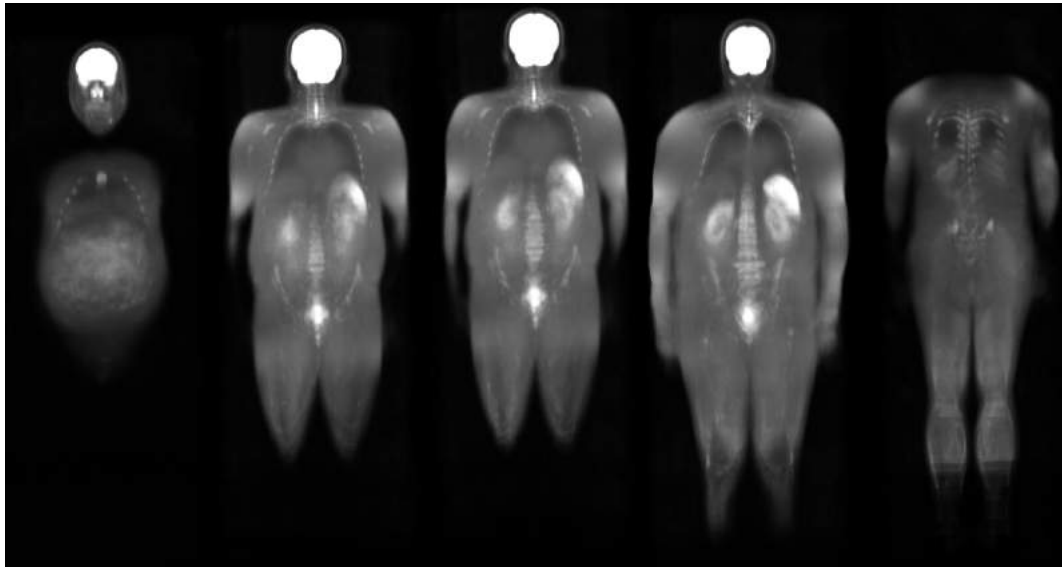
Male template image, built with 18 DWI images and using the first template image built with 18 images as the fixed image. These five representative coronal slices do not show differences in the brain, spleen and bladder, when compared to the first male template. The kidneys, hip bones and vertebrae are converging to specific areas, achieving better alignments.
